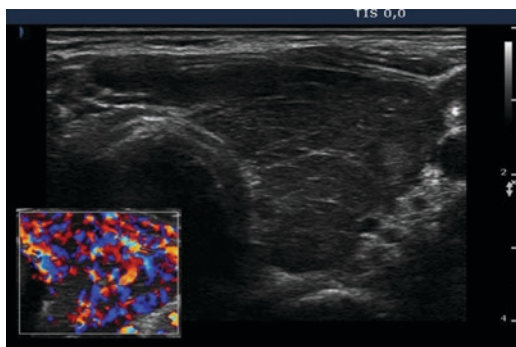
Ultrasound images showing hypervascularity and a hypoechoic pattern of the thyroid gland
